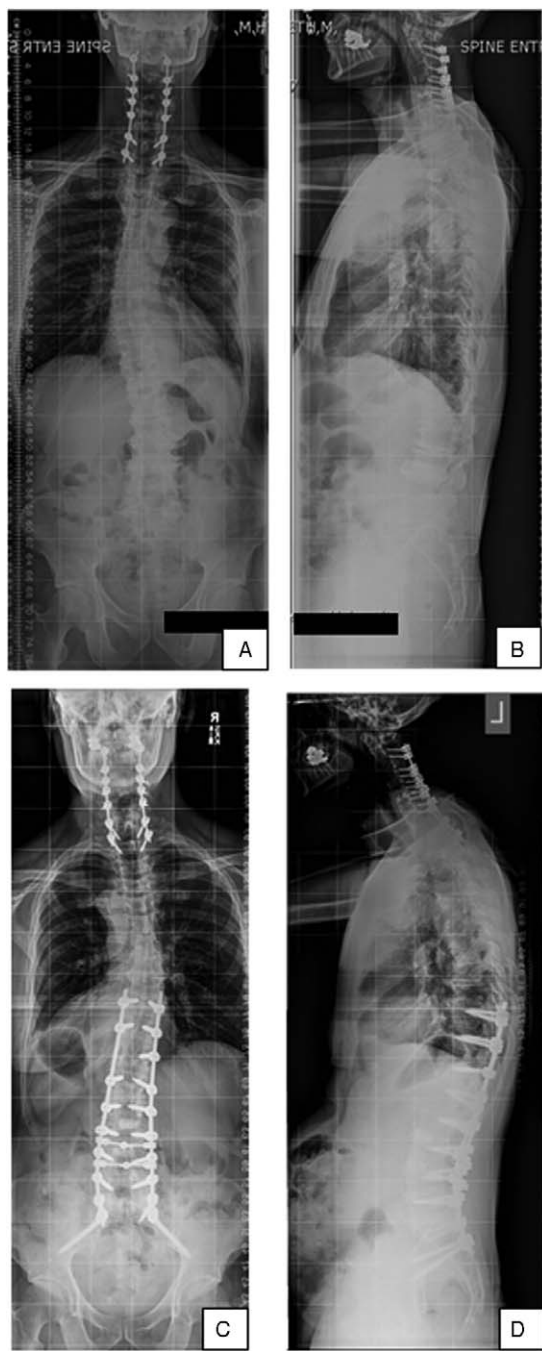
AP (A) and lateral (B) radiographs of a 64-year-old man. He was 5-years status post-L1-L5 laminectomy for lumbar stenosis but had developed disabling recurrent radiculopathy and sagittal imbalance due to lumbar kyphosis. SVA was -0.22 cm and PI-LL was 27.5° . Preoperative LSDI was 36, ODI was 50, PCS was 29, and SRS-22 was 2.36. AP (C) and lateral (D) radiographs taken 2 years status poststaged posterior arthrodesis from T10 to pelvis, followed by anterior discectomy and fusion from L2-S1. SVA was -0.8 cm and PI-LL was 4.6° . LSDI was 39, ODI was 38, PCS was 34, and SRS-22 4.05. SRS-22 Satisfaction score was 5 (very satisfied and would elect same treatment again).
